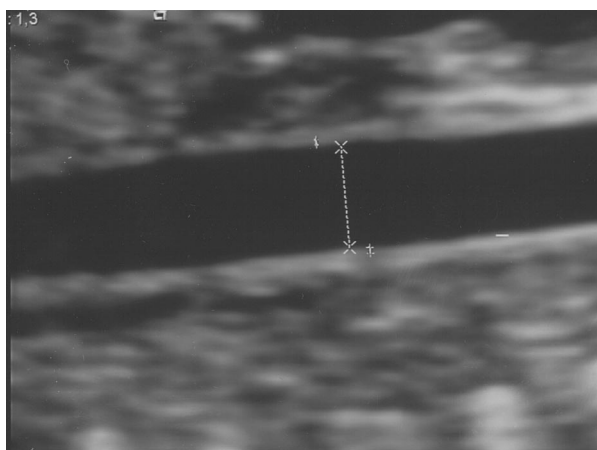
Ultrasound image showing measurement of aortic intima media thickness and aortic diameter in a fetus. *Cosmi. Aortic Intima Media Thickness. Obstet Gynecol 2009.*
